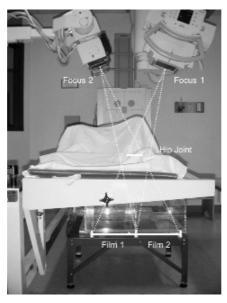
Set-up for an RSA X-ray. The hip joint is positioned in the focus of two X-ray machines for an exact location of the object in space (Bottner et al. 2005).
